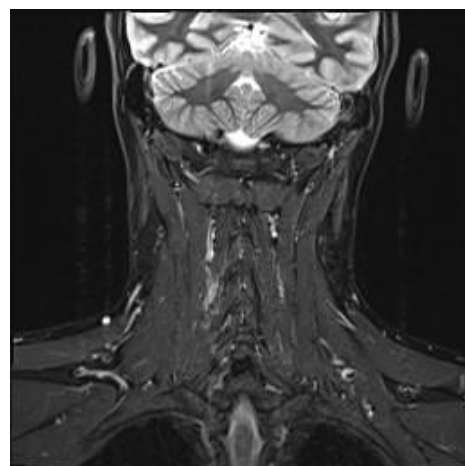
MRI scan showing complete resolution of the abscess
